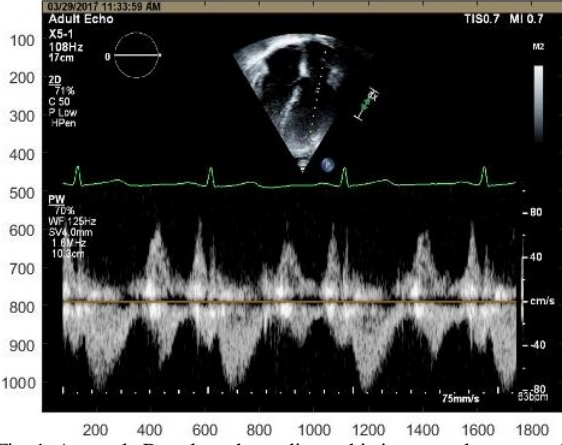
A sample Doppler echocardiographic image at the center of the mitral valve taken from a 55-year-old male subject with no history of heart disease. The horizontal and vertical axes represent the number of pixels.
